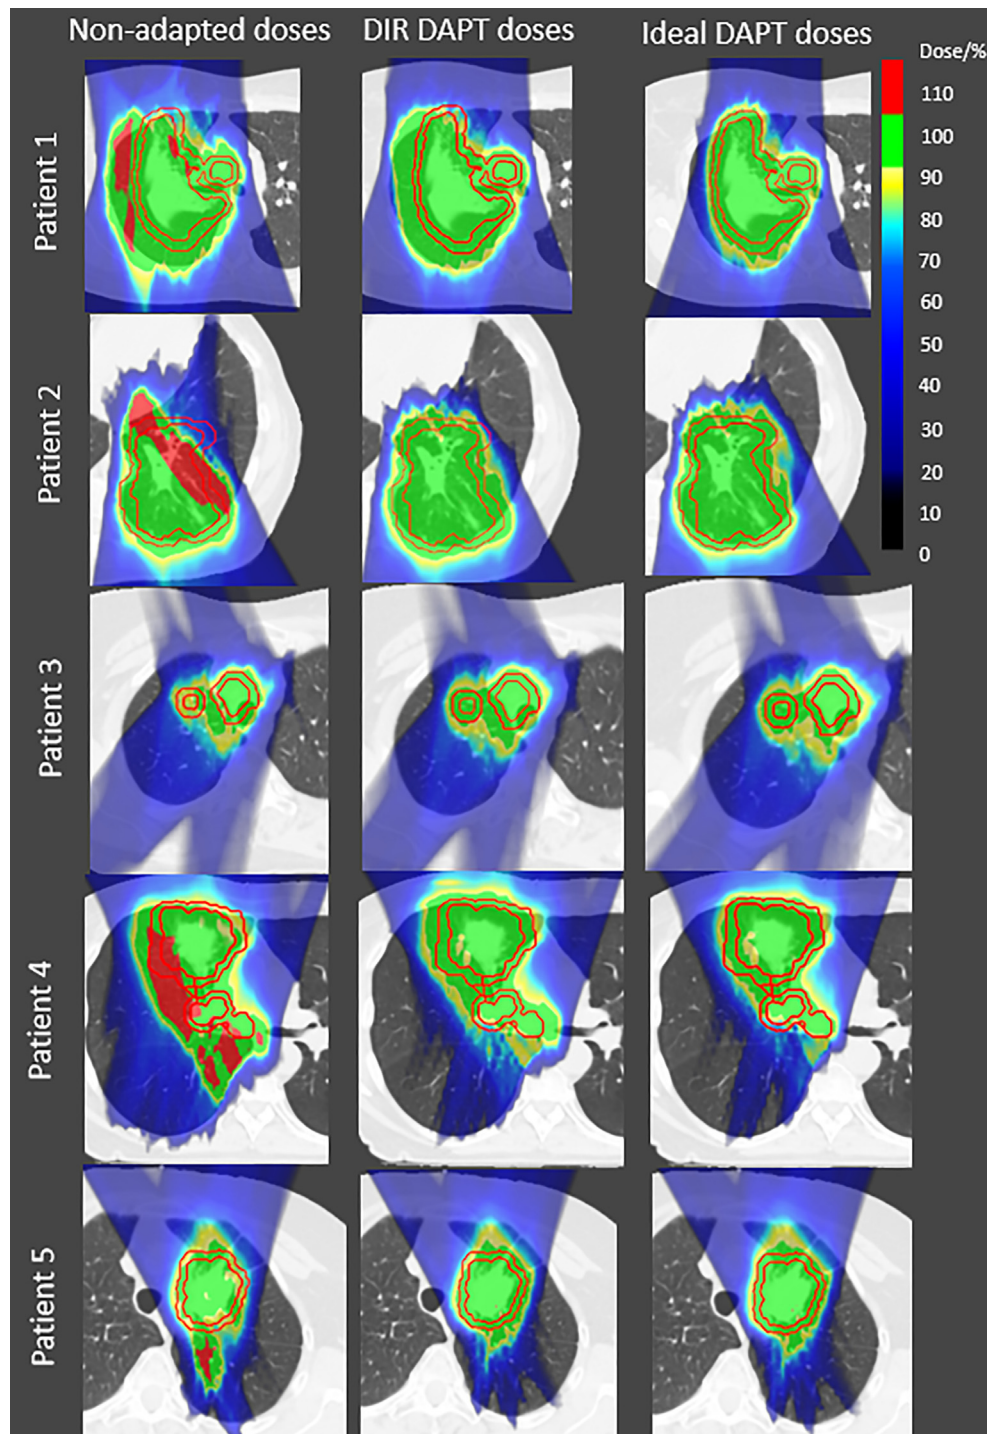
Example slice of the *non-adapted dose*, *DIR DAPT dose* and the *ideal DAPT dose* of a CT at the end of treatment for all patients. Reference CTV and PTV structures of this CT are shown in red.
